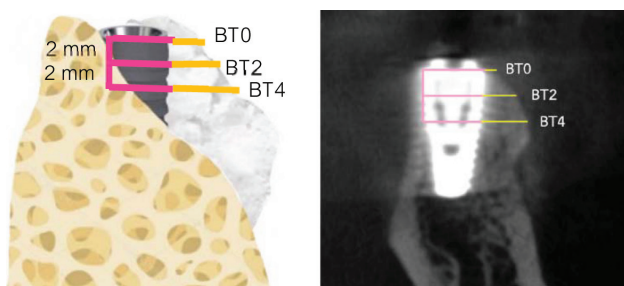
Radiographic measurements of buccal bone thickness. The vertical reference lines aligned with the implant center, in conjunction with horizontal lines at three specific levels ; at implant platform(BT0), 2- mm (BT2), and 4-mm (BT4) below the platform level.
